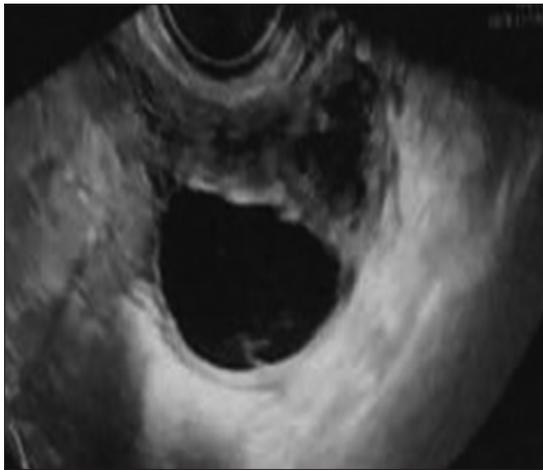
Sonography pelvis reveals Tubo-ovarian cystic mass.
